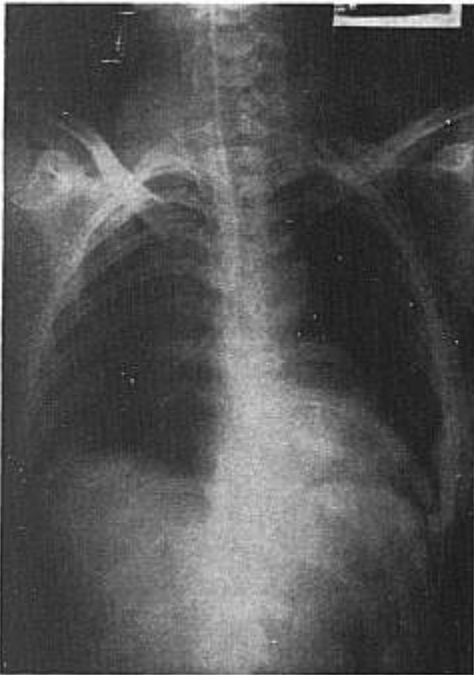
Chest x-ray demonstrating bronchial catheter in place.
